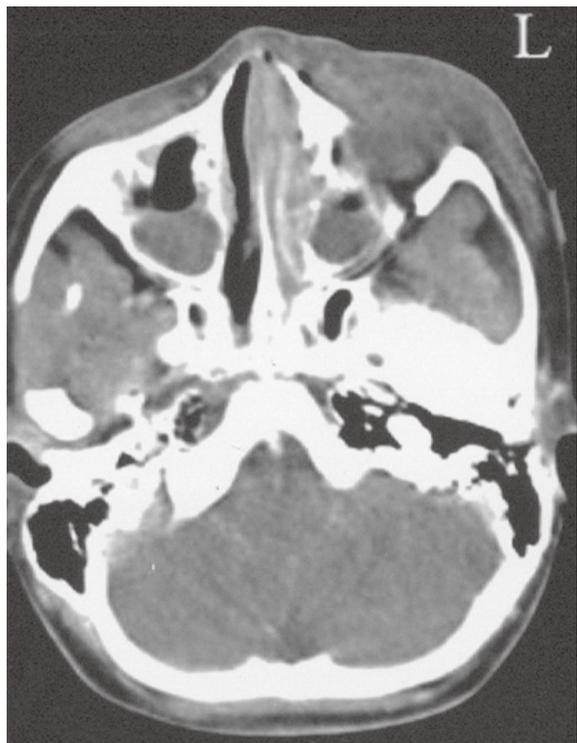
Axial CT image shows left-sided maxillary sinusitis with osteomyelitis and facial soft tissue swelling
